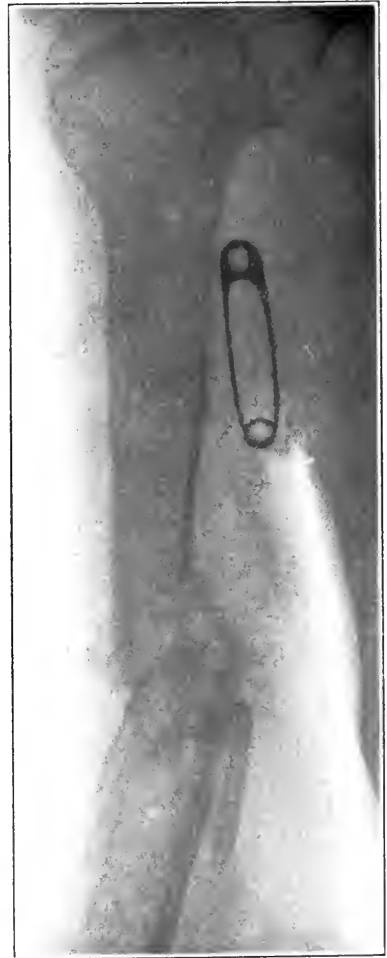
Case 9. X-ray picture taken after firm union had resulted.
